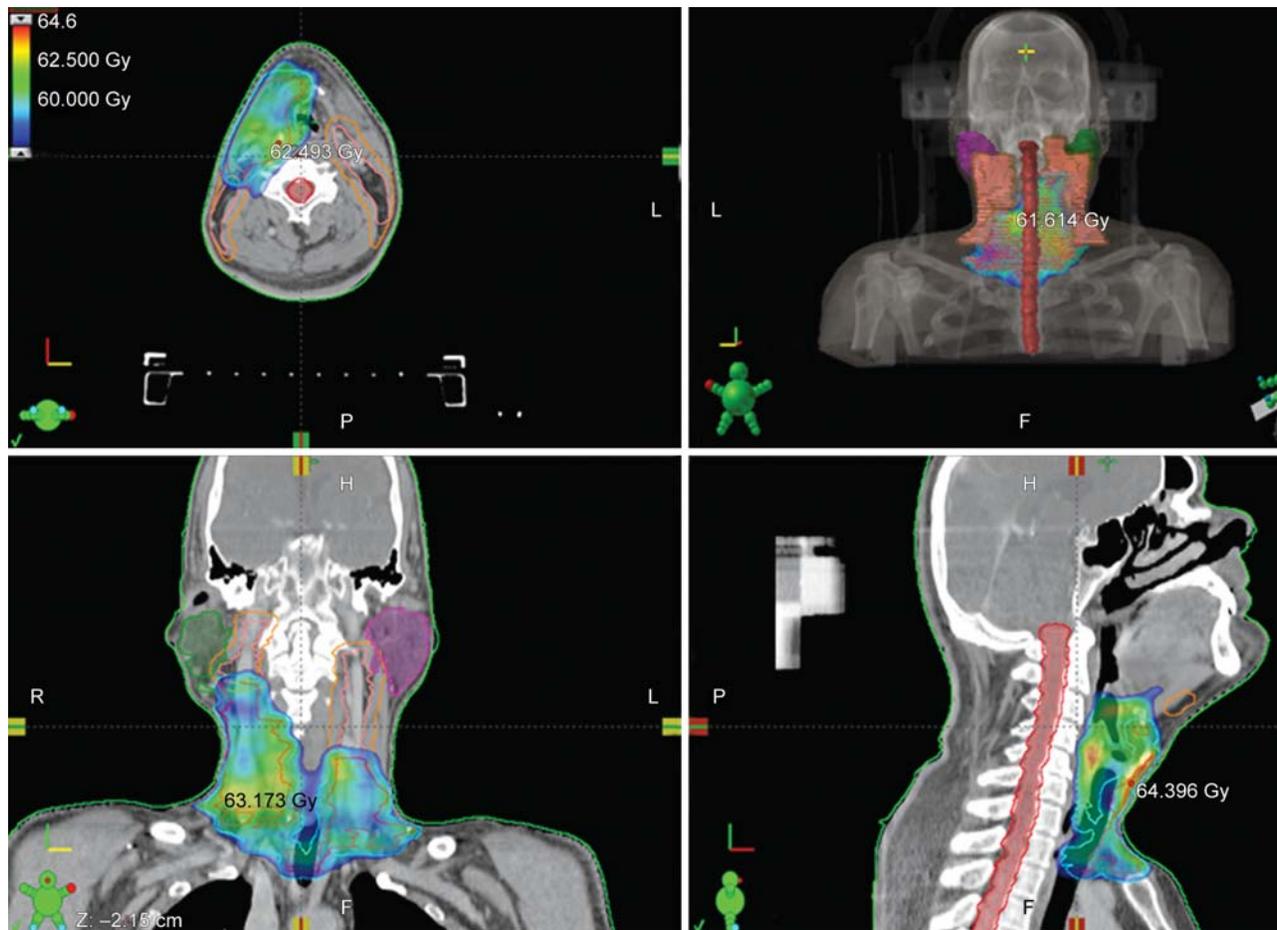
IMRT treatment planning: Transverse, frontal, sagittal and digitally reconstructed radiograph (DRR) based planning images of a 50 years old papillary carcinoma thyroid patient. Contours of CTV1 (60 Gy, blue) and CTV2 (54 Gy, orange) and isodose curves are shown
